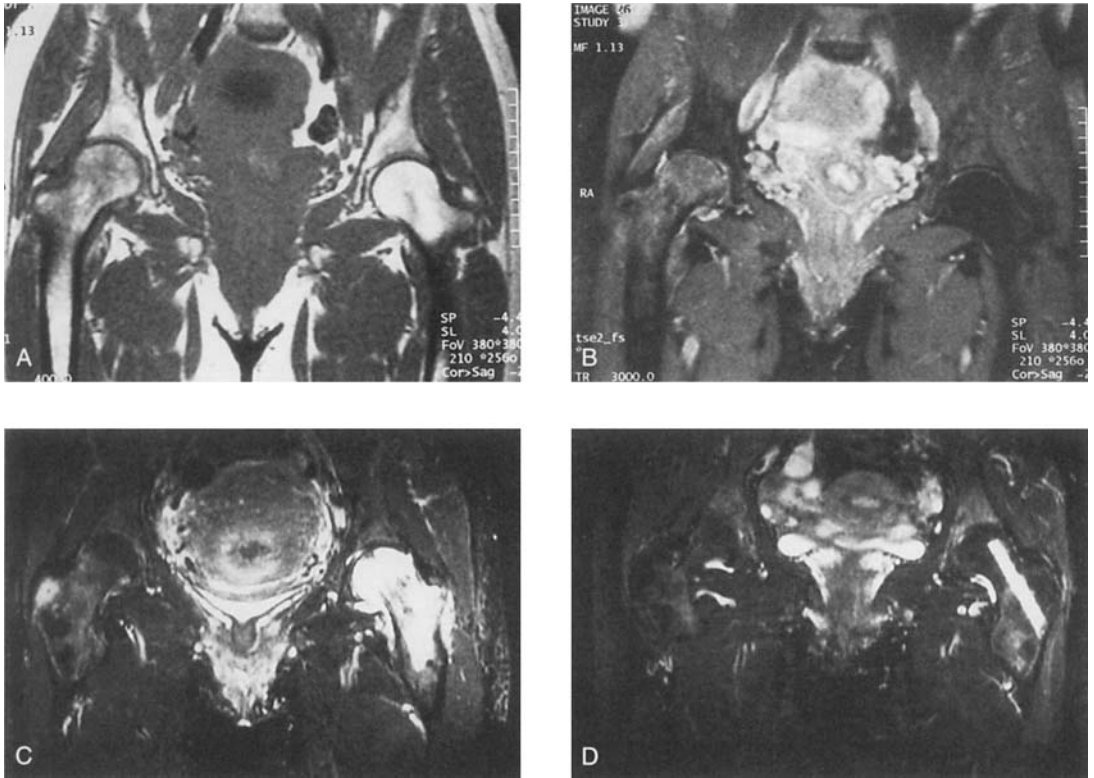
Magnetic resonance imaging scans of Patient 1. (A) Coronal T1-weighted and (B) fat suppressed T2-weighted images at the 23rd of pregnancy. In the right femoral head and the intertrochanteric region, diffuse signal attenuation on T1-weighted images is mirrored by hyperintensity on T2-weighted images. (C) Identical coronal section, short tau inversion recovery sequence obtained shortly after delivery. Marrow edema of the right hip has resolved completely, and extensive bone marrow edema is present in the left femoral head and intertrochanteric region. (D) Identical coronal section, short tau inversion recovery sequence obtained 6 months after core decompression. Bone marrow edema has resolved in both hips. The drilling channel still is visible in the left hip.
